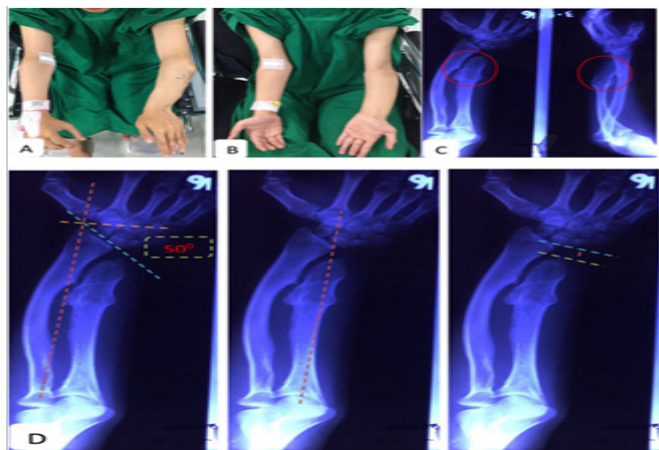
(A and B) Clinical picture showing limitation of pronation (range of motion 0-50°) and normal limit for supination (C) Plain radiograph of distal ulnar exostoses, ulnar shortening and without dislocation of left radial head (Masada type I deformity) (D) Radiographic measurement showing 50° for RAA, abnormal CS and -30 mm ulnar variance
